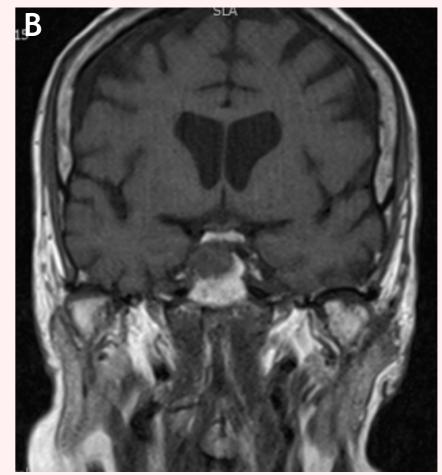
MR imaging of the sellar region demonstrated an enlarged pituitary gland – preoperative image [A]. Postoperative imaging showed significant residual tumour burden [B].
